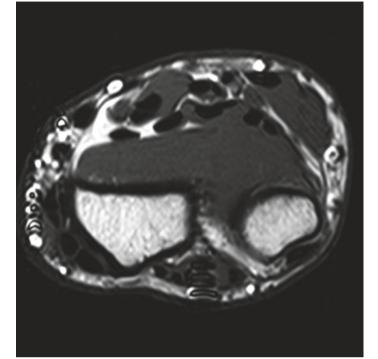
MRI scans in the forearm through the ulnar nerve
